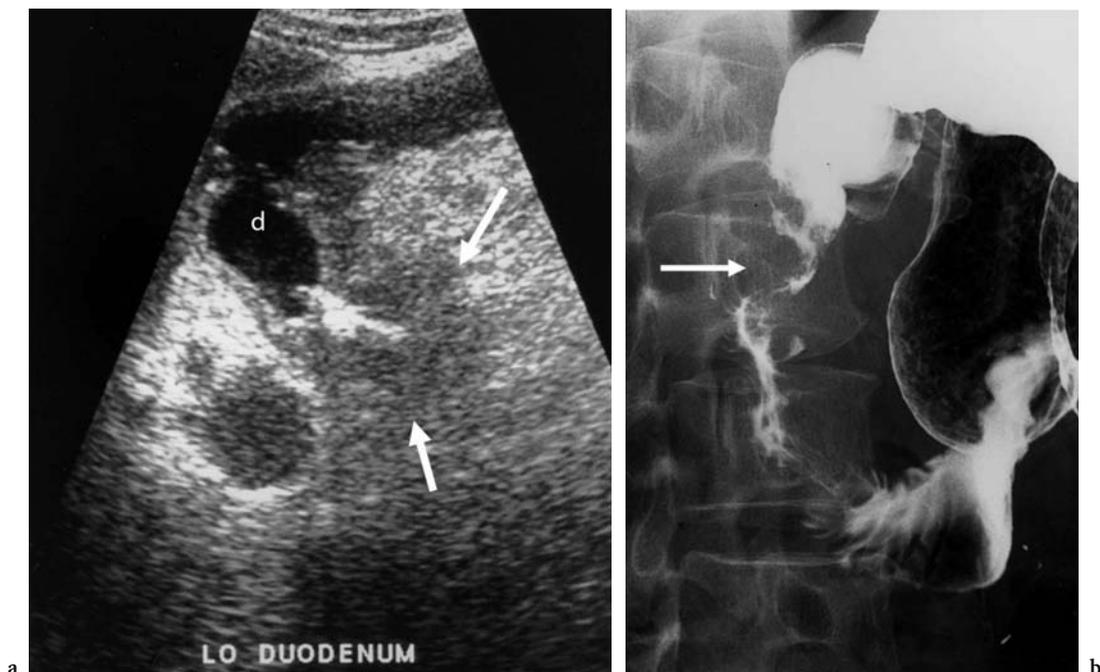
Duodenal obstruction by adenocarcinoma. a Sagittal sonogram of the right upper abdomen discloses a mass (arrows) with dilated first part of the duodenum (*d*). b Upper gastrointestinal series shows near-complete obstruction by adenocarcinoma (arrows)
